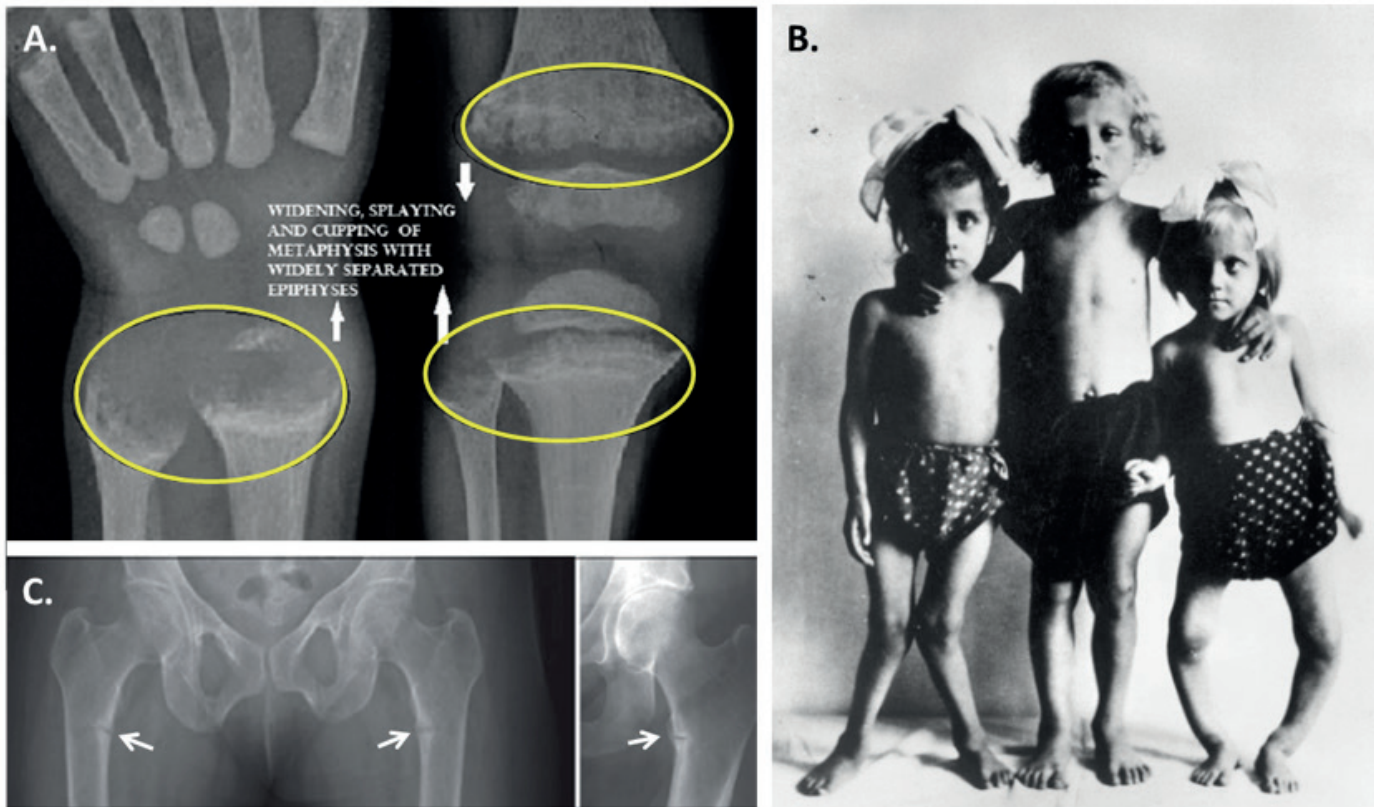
Features of rickets and osteomalacia. (A) Radiographs of the distal forearm and knee showing typical rachitic characteristics i.e. widening, cupping and fraying of the metaphysis (circles) (image adapted from [20]. (B.) Photograph taken in Scotland during the early 1900 where vitamin D deficiency secondary to low sun exposure and poor dietary intake was very prevalent (image adapted from [21]. The image shows children with rickets with lower limb bowing deformations and growth impairment. (C.) Pseudofractures at the femoral shaft (arrows) in an adult patient with osteomalacia (image adapted from [23]).
